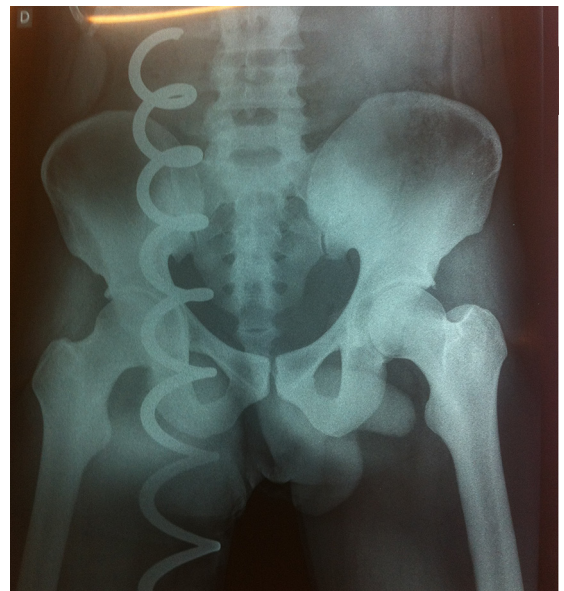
X-ray of the patient's right thigh and hips, showing the metal object penetrating the right abdomen up to the level of the second lumbar vertebra.
